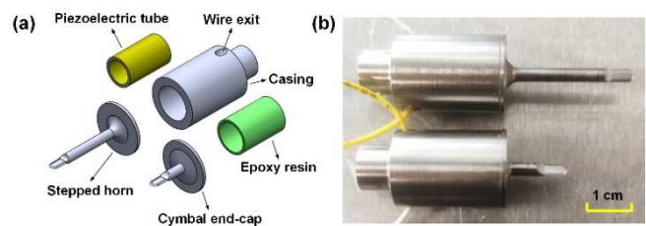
Ultrasonic surgical devices based on a piezoelectric tube: (a) device components, (b) fabricated ultrasonic surgical devices (top: device excited by the longitudinal mode of the tube with a stepped horn, bottom: device actuated with the breathing mode of the tube with a cymbal end-cap)
